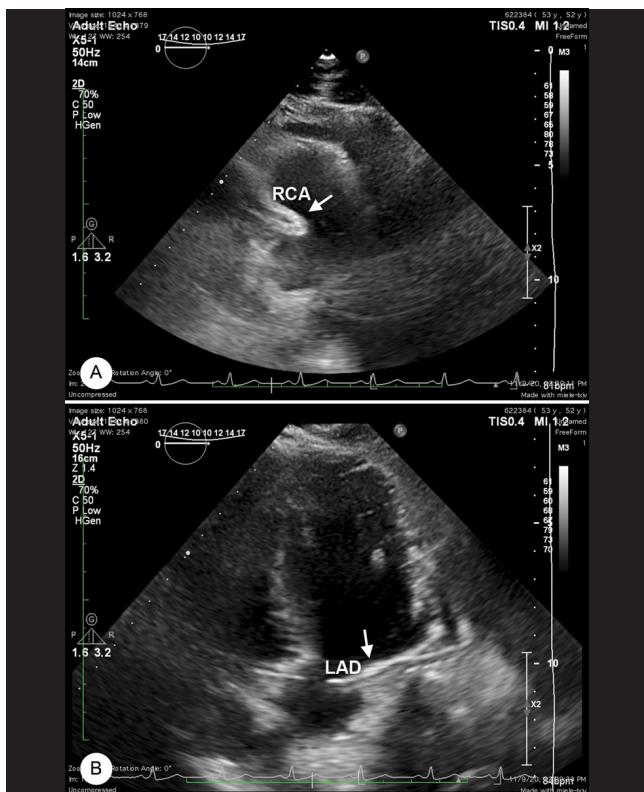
Transthoracic echocardiography shows the RCA in the aortic short-axis view (A) and LAD₁ and LAD₂ in the 5-chamber view (B).
